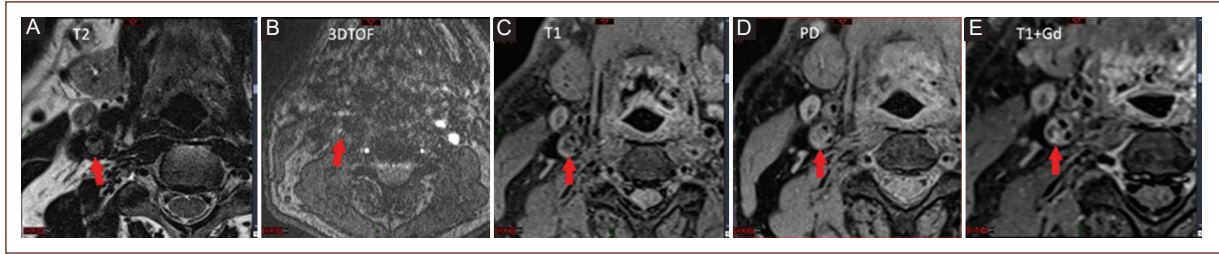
Severe left atherosclerotic carotid disease with a vulnerable plaque assessed with magnetic resonance imaging. Arrows in A and C point to the lipid-rich necrotic core. Arrow in B points to a severely decreased flow due to the stenosis. Arrow in D reveals intraplaque hemorrhage. The arrow in E shows enhancement after gadolinium. PD is hyperintense compared to T2. 3D TOF: 3D time-of-flight; PD: proton density; Gd: gadolinium.
